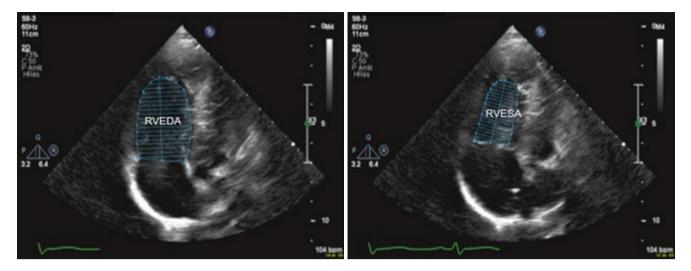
demonstrates 2D-echocardiography with tracing of the RVEDA and RVESA to obtain the FAC of the right ventricle (Courtesy of N. Sekarski, MD). FAC fractional area change, RVEDA right ventricular end-diastolic area, RVESA right ventricular end-systolic area
